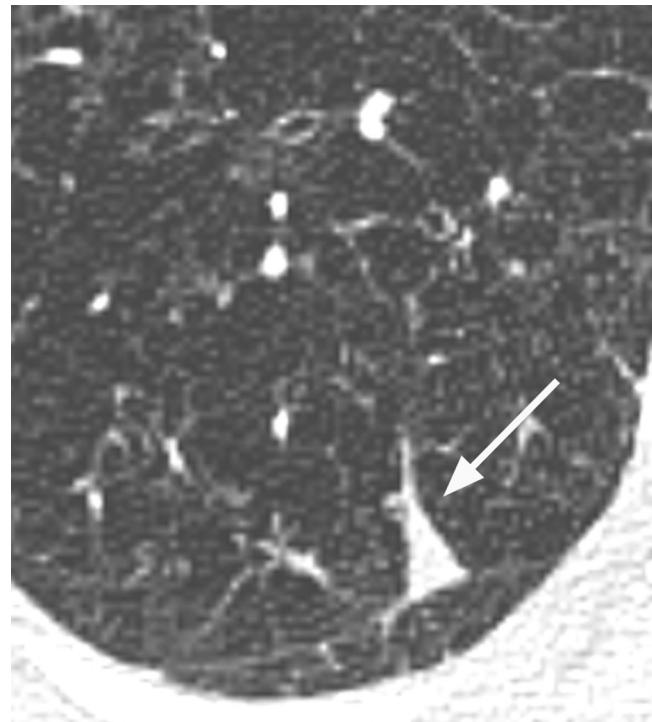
Perifissural opacity. Axial baseline computed tomography, demonstrating a 10×6 -mm, solid, well-defined nodule (arrow) along the path of the right major fissure in a patient who was a high-risk smoker. This is characterized as Lung Reporting and Data System 2 (benign nodule).
